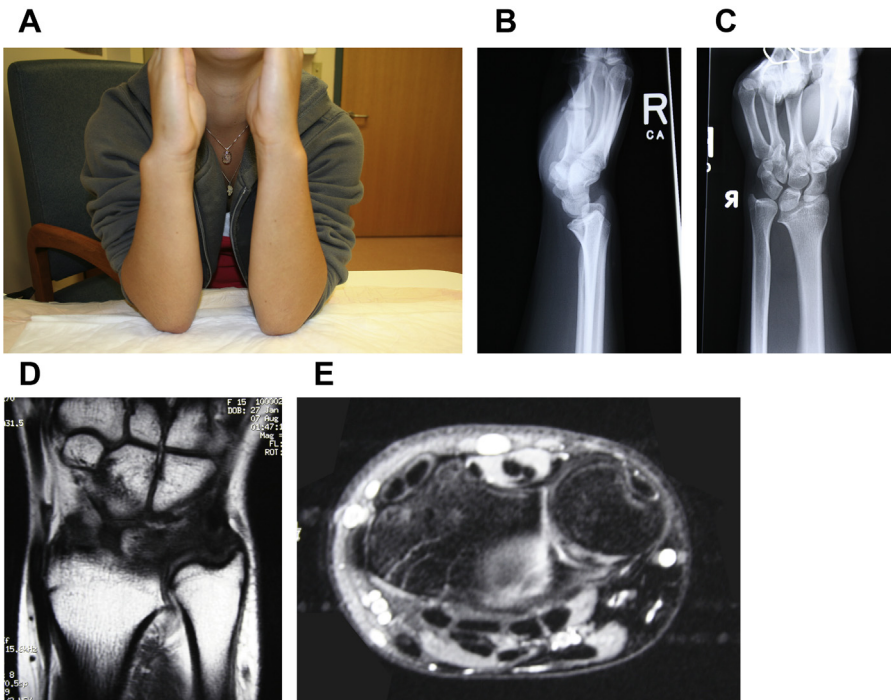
Chronic gymnast wrist with physal arrest. A 16-year-old female gymnast presented with wrist deformity (A) and pain. Radiographs showed a “Madelung” type deformity with growth arrest of the distal radial volar/ulnar corner in a skeletally mature wrist (B, C). MRI did not show a Vicker ligament (D, E), consistent with her history. The absence of a Vicker ligament confirms that her etiology was not a true Madelung case, but rather most likely the result of repetitive trauma or acute injury to the physal. (Courtesy of Shriners Hospital for Children Philadelphia.)
